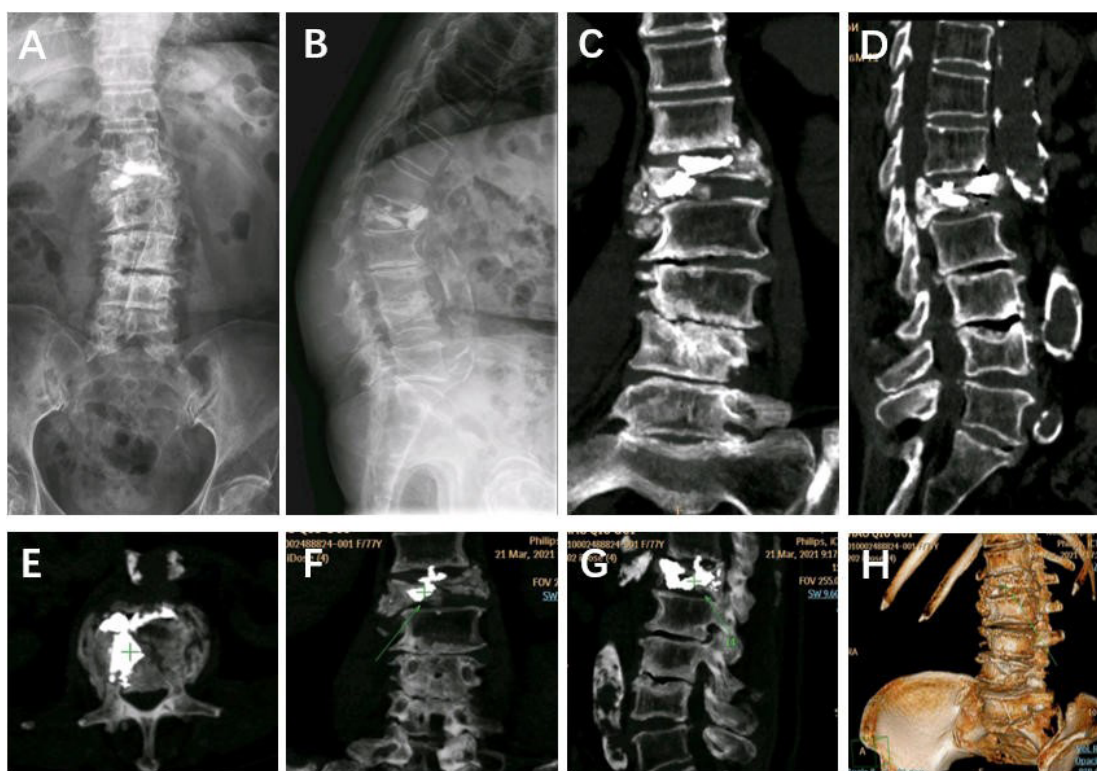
Lateral cement displacement following vertebral augmentation in a 68-year-old female with an osteoporotic L2 compression fracture. (A, B) Follow-up radiographs demonstrating lateral displacement of cement from the treated vertebral body. (C–H) Computed tomography images with three-dimensional reconstructions showing the spatial relationship between the displaced cement and surrounding vertebral structures.
